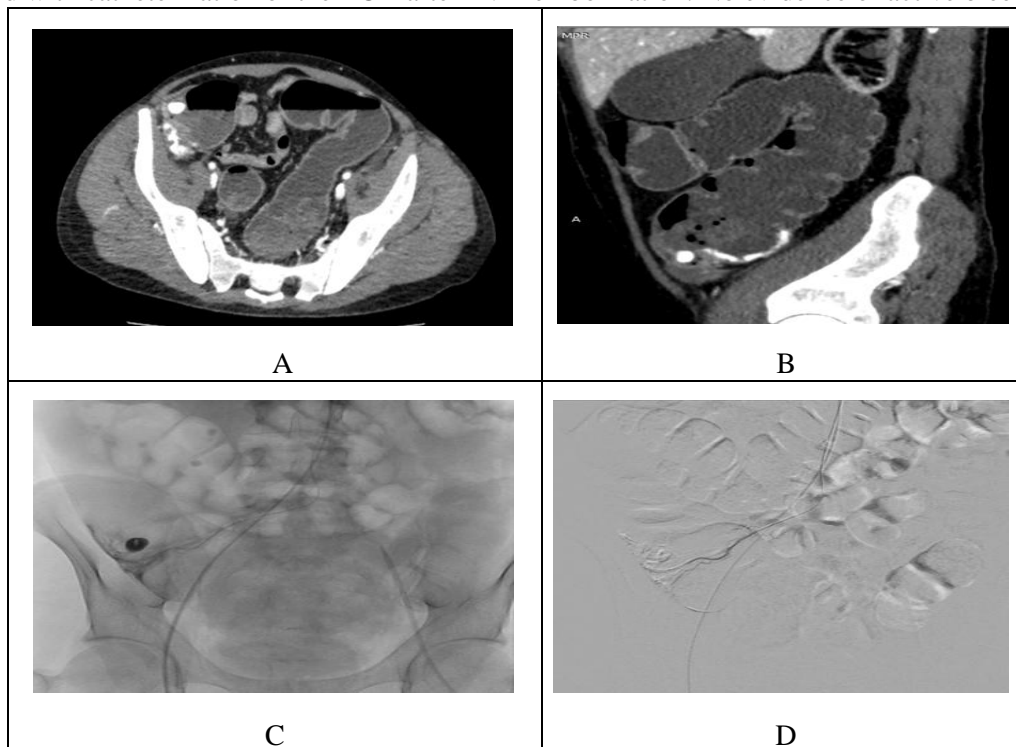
Colonic pseudoaneurysm. (A-D) CT angiography (CTA) and digital subtraction angiography (DSA) of an 32-year-old male patient with acute lower gastrointestinal tract bleeding (A-B) CTA identified active arterial bleeding in the region of the ascending colon. (C) DSA showed pseudoaneurysm originating from the ileocolic artery (D) The final mesenteric angiogram confirms that the entire remaining bowel is still adequately perfused while the pseudoaneurysm was obliterated.
